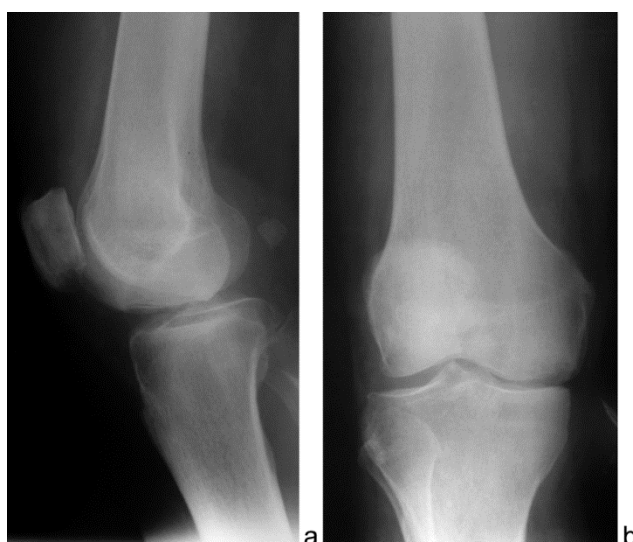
Preoperative radiographs of the right knee joint of patient G.: a – lateral view, b – AP view
